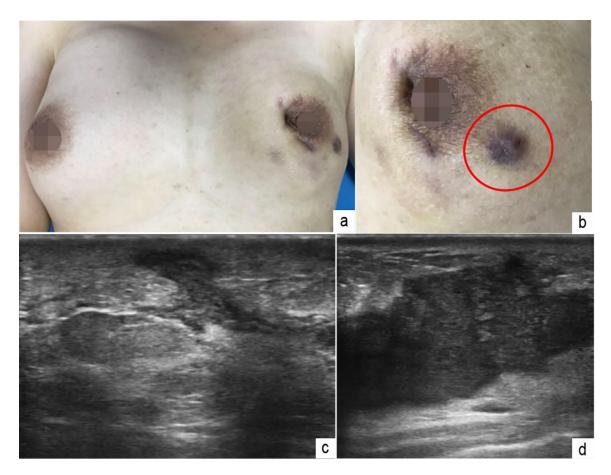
Abscess formation stage. a, b Granulomatous lobular mastitis in a 35-year-old woman with a palpable mass of 4 weeks' duration in the outer lower quadrant of the left breast, with hyperaemia and swelling skin, without nipple retraction. c, d Irregular anechoic areas and abscesses $(3.9 \text{ cm} \times 1.9 \text{ cm})$ were detected by ultrasound
